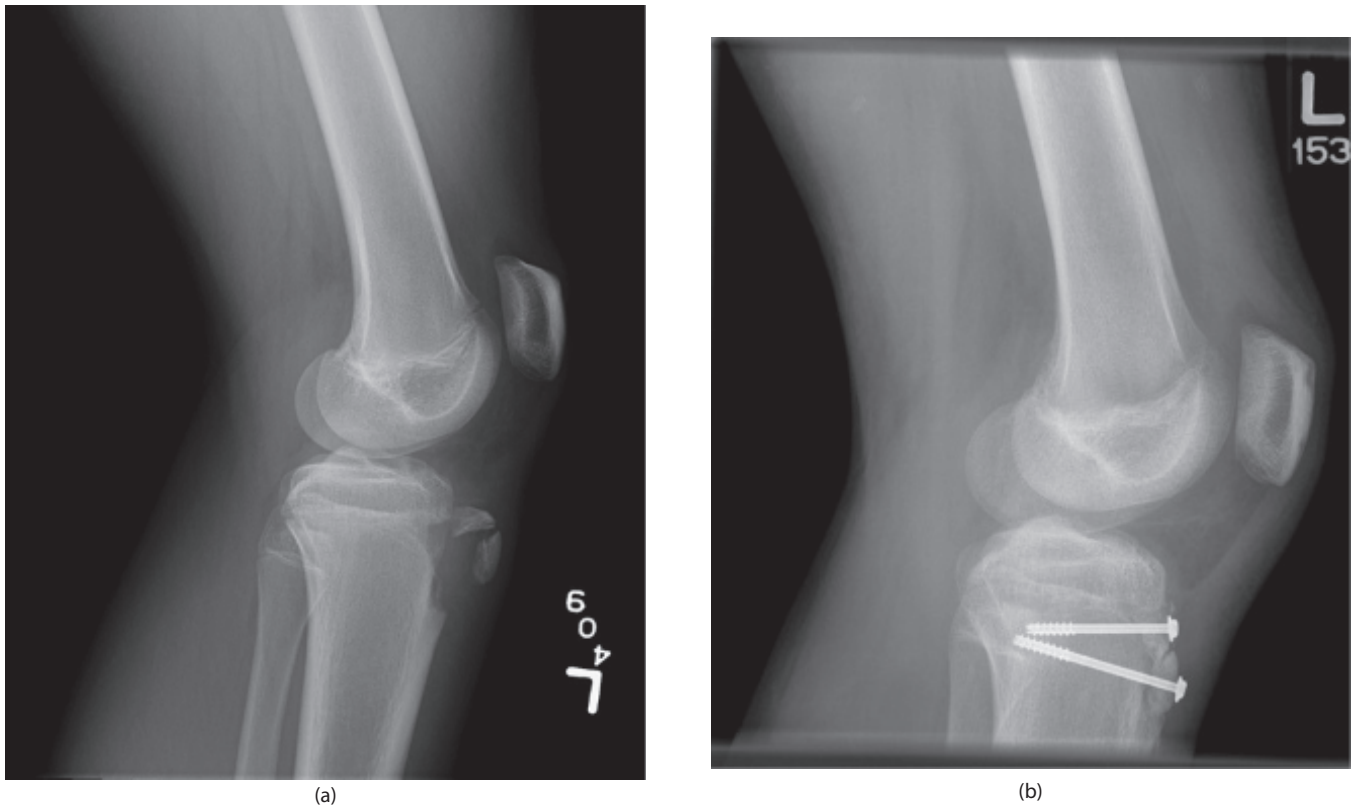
(a) and (b) Radiographs of a 14-year-old male who sustained a displaced, comminuted tibial tuberosity fracture resulting in patella alta while playing basketball. His fracture was treated with open reduction and screw fixation.
